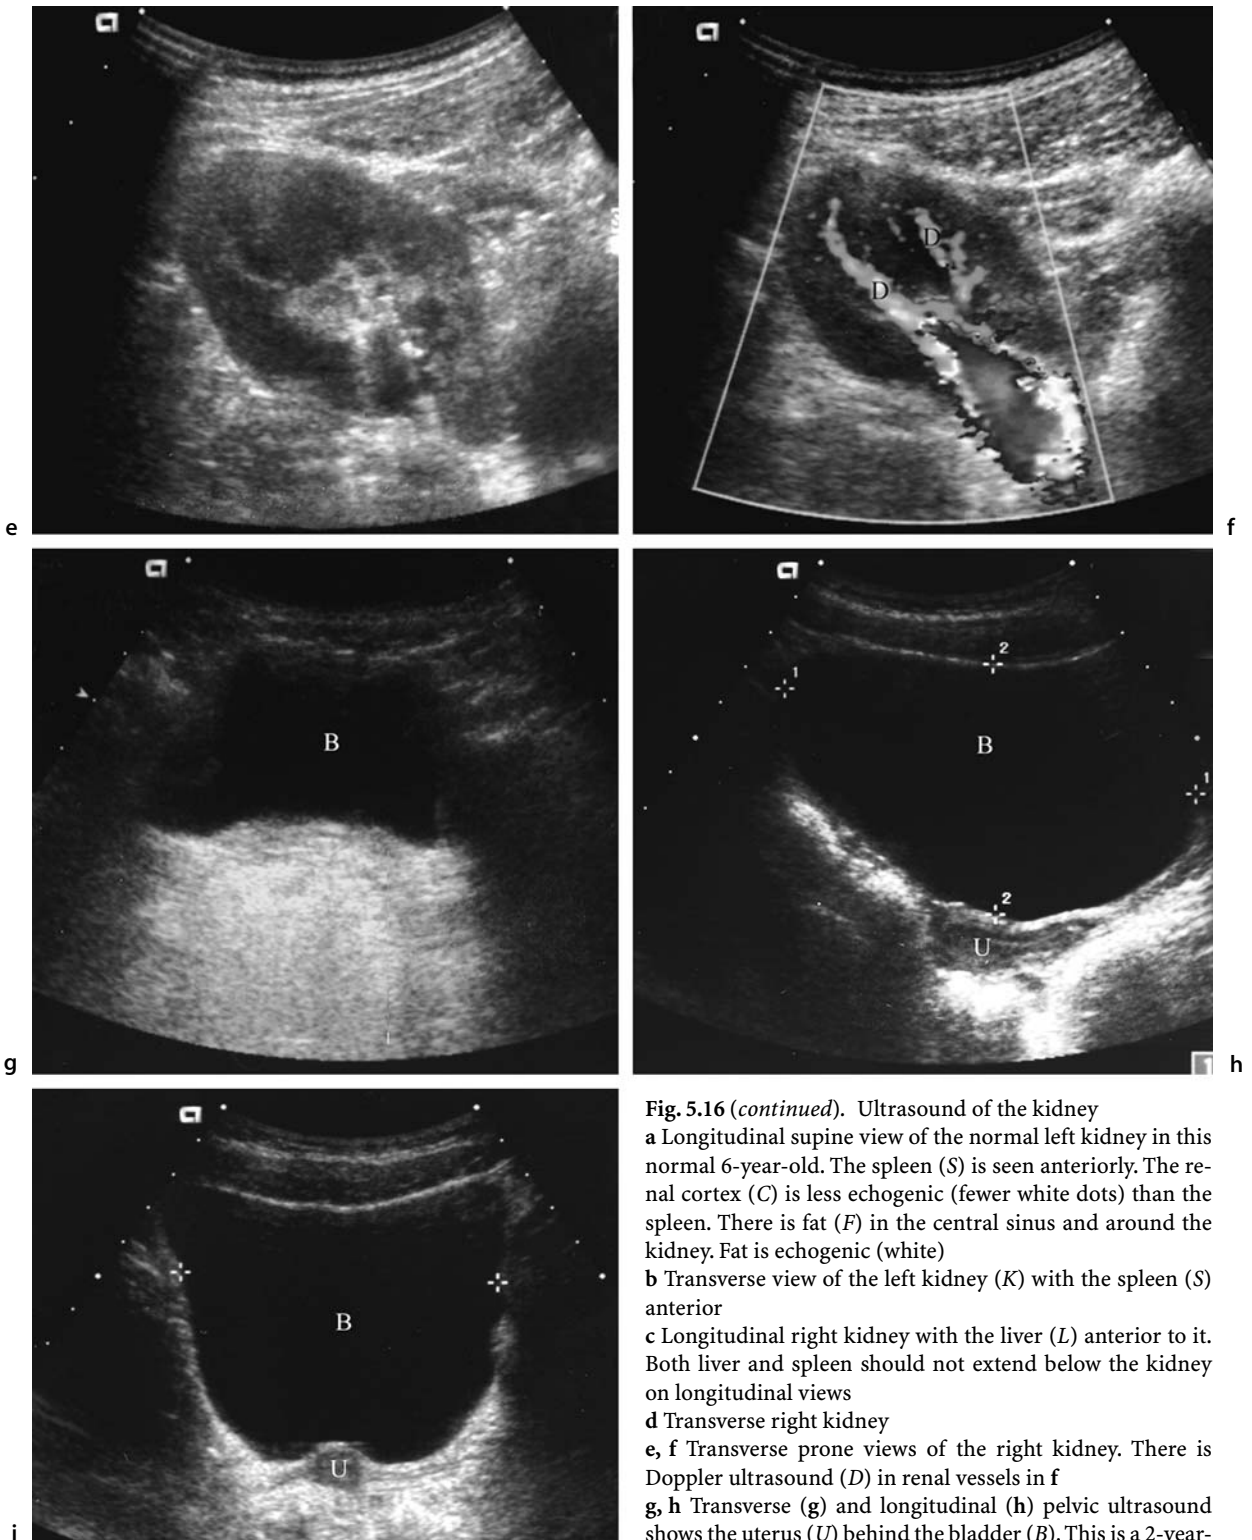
(continued). Ultrasound of the kidney
